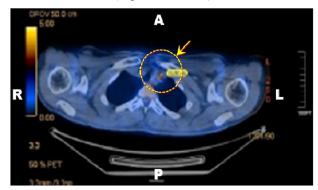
PET-CT scan: residual metabolically active tissue (yellow circle and arrow). A: Anterior; L: Left side; P: Posterior; PET-CT: Positron emission tomography-computed tomography; R: Right side.
